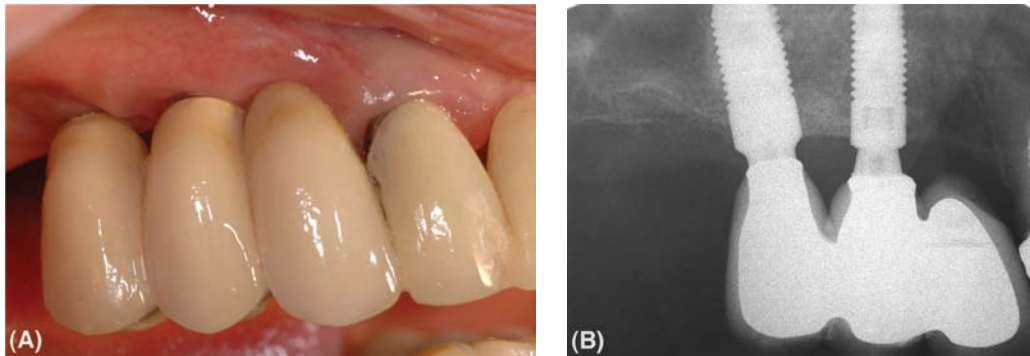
(A) A patient with a three-unit implant-supported bridge in the upper right quadrant distal to the lateral incisor. The bridge has long crowns because of pronounced vertical bone resorption following tooth loss. (B) Radiograph showing sufficient bone to engage implants of 11 mm in length. Lip coverage was favorable.
